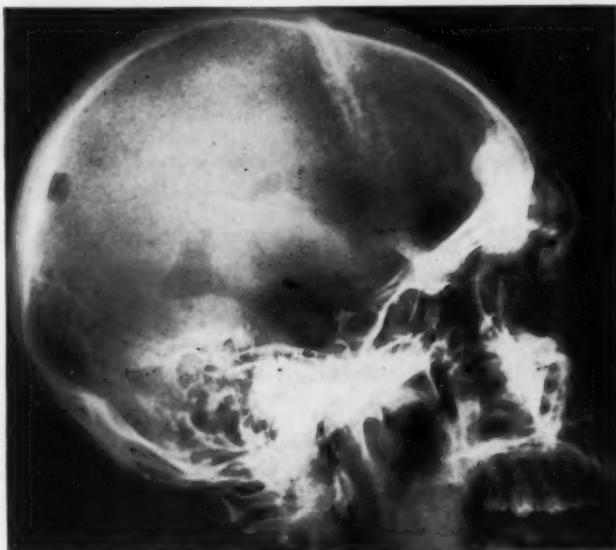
Case 6. A.R. Lateral X-ray film showing tumor mass in frontal sinus, thickening or opacity in area of posterior plate, and peculiar abnormal shades and shadows in the frontal cerebral lobe.
